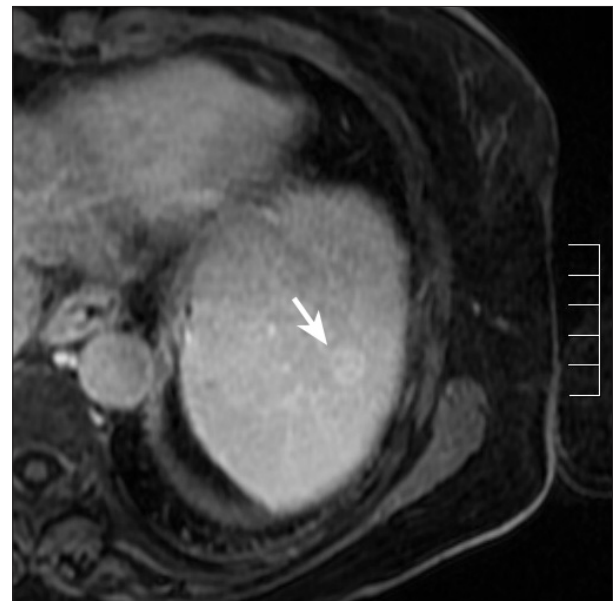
(continued) E, T2-weighted axial fast spin echo image showing a homogeneously hyperintense round lesion (arrow). F and G, On contrast-enhanced magnetic resonance imaging obtained in the arterial phase, the lesion is hypointense (F, arrow) but shows complete fill-in 10 minutes after contrast medium injection (G, arrow).
